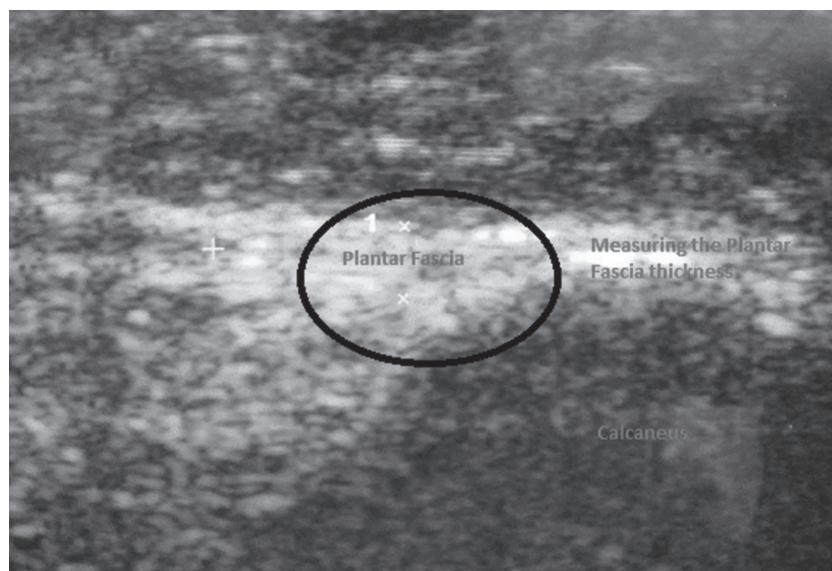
Ultrasound of plantar fascia performed in office.
